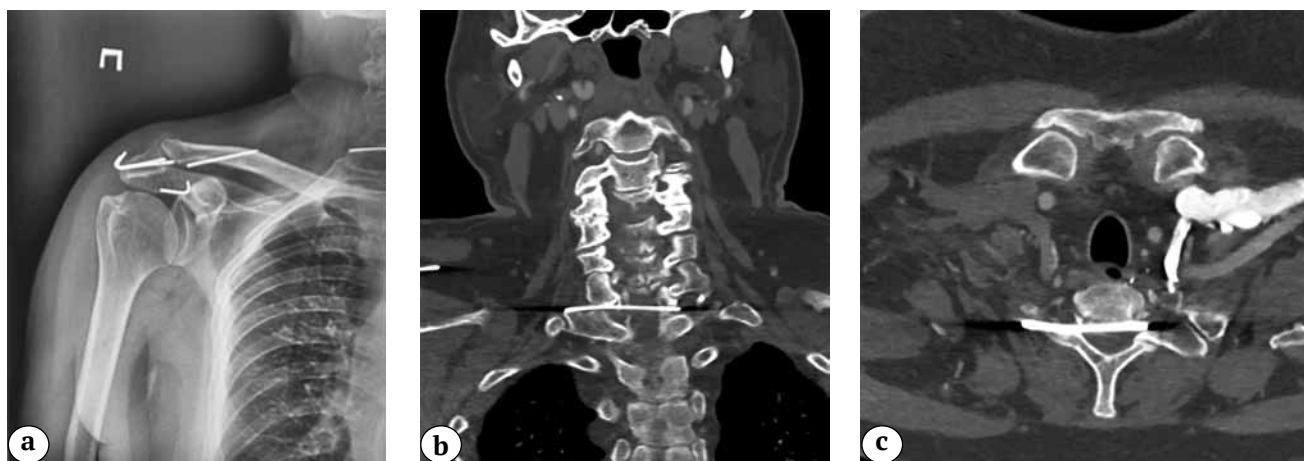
Preoperative cervical spine X-ray images:
